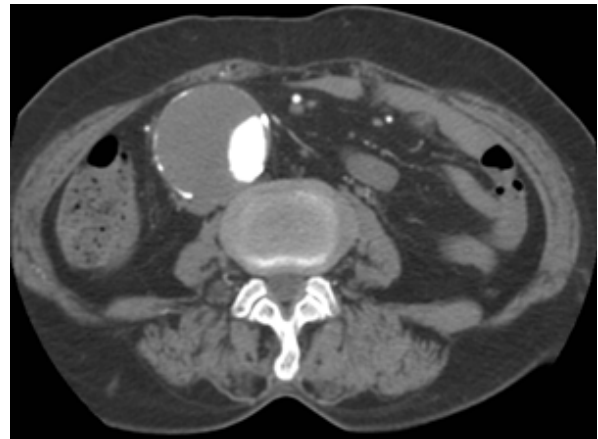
Axial CT scan shows AAA with luminal thrombosis. Interventional Radiology
